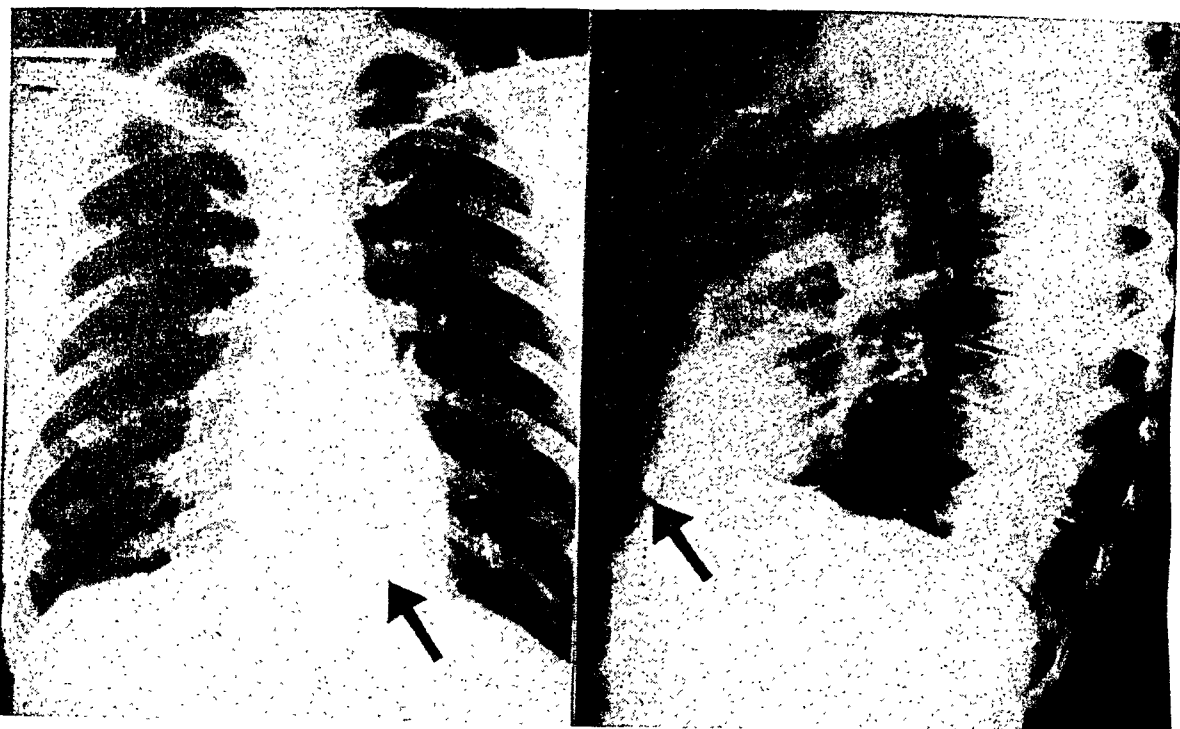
Preoperative roentgenograms of the chest demonstrating the piece of shrapnel lodged in the diaphragmatic surface of the heart.
